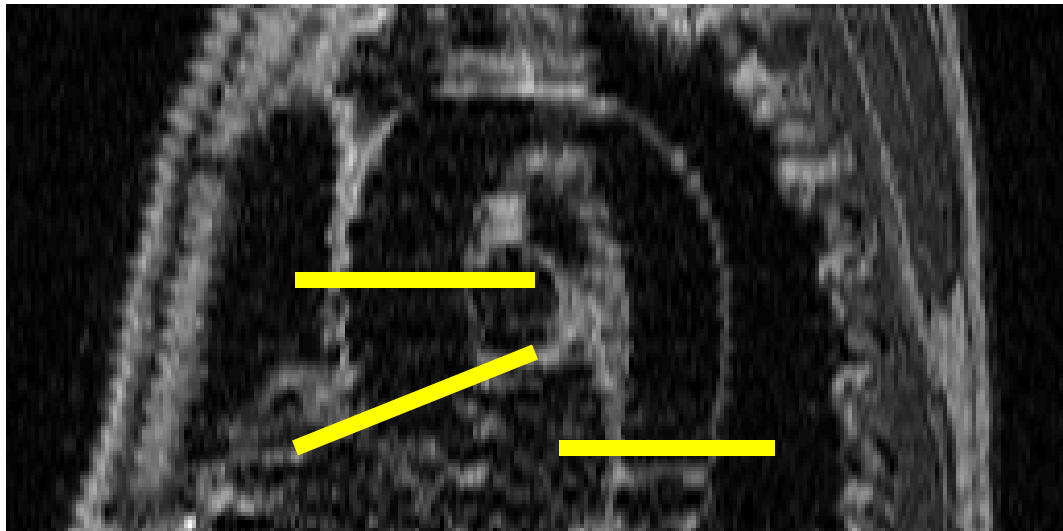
PC-MRI scanning was performed at three sections (yellow lines) in the aorta where the left lumen is the ascending aorta and the right lumen is the descending aorta.
